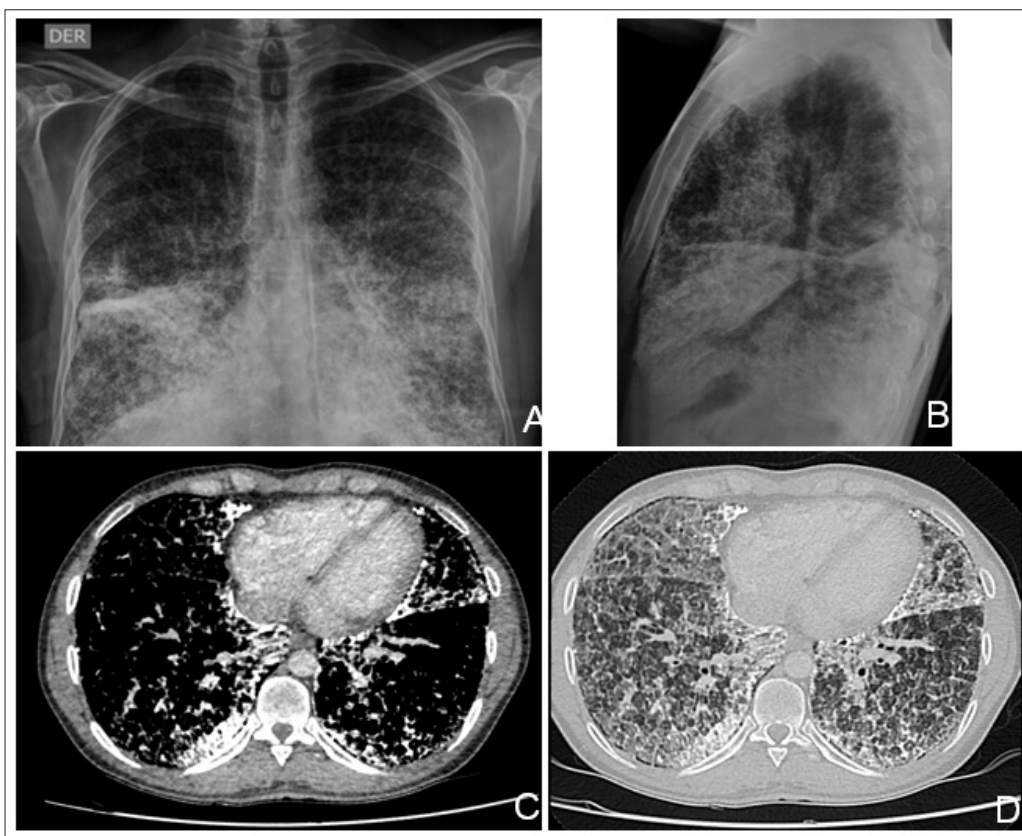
Chest X-ray AP and lateral views, respectively showing multiple calcified nodular opacities bilaterally distributed, predominantly in the basal and hilar regions. C. High-resolution chest CT scan, mediastinal window, axial section, demonstrating calcified subpleural and peribronchovascular nodules. D. Pulmonary window, axial section, revealing thickening of interlobular septa associated with ground-glass opacities arranged in a disordered “crazy-paving” pattern.
